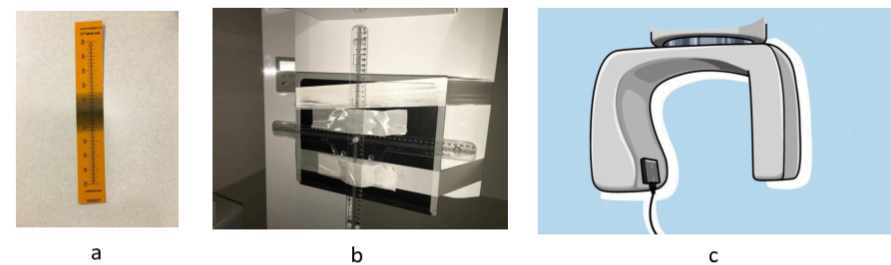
Three methods for measuring the CBCT radiation field area. (a) Radiochromic self-developing film (b) CR storage phosphor cassette affixed to image receptor (c) electronic beam edge/width detector
